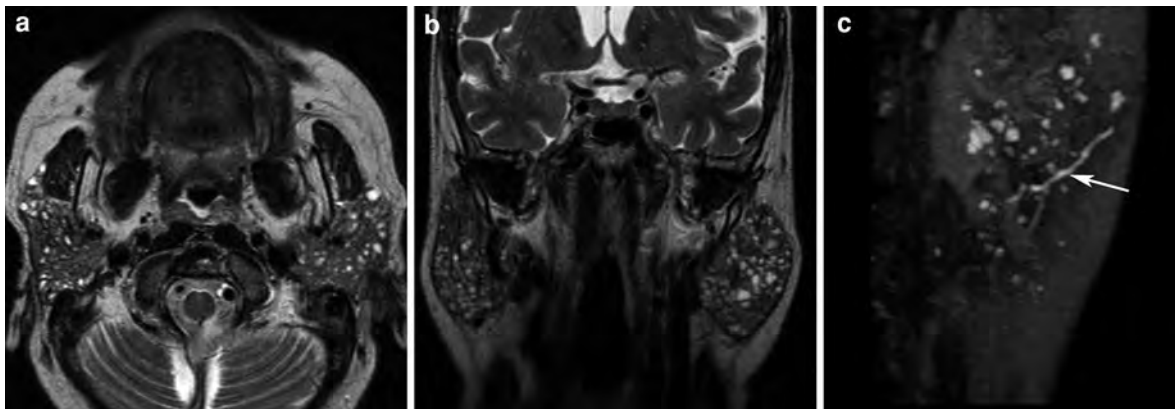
Miliary pattern appearance of multiple cystic lesions throughout both enlarged parotid glands, showing high T2-weighted signal intensity, in a patient affected by Sjögren syndrome (a, b). These cystic lesions and the normal salivary ducts (arrow) are well seen on MR sialography (c)
